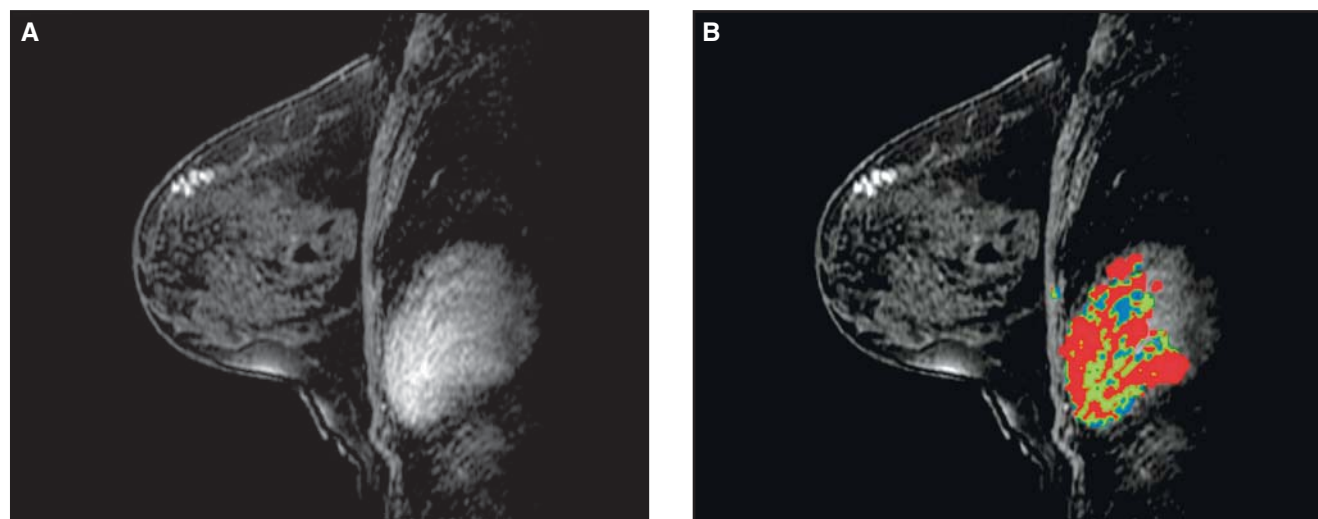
Magnetic resonance (MR) images of a left breast in a 51-year-old asymptomatic woman with a history of prior right breast carcinoma. A. Sagittal, fat-suppressed, T1-weighted, 3-D spoiled gradient recalled immediate postgadolinium image demonstrates nonmass-like segmental enhancement in the upper inner quadrant. B. Same image with computer-aided evaluation applied demonstrates the lesion does not meet the minimum enhancement threshold of 100%, indicated by lack of color overlay at the site. The lesion also did meet the enhancement threshold of 50% (not shown). MR biopsy demonstrated benign fibrosis and ductal hyperplasia. (Image courtesy of Wendy DeMartini, M.D., University of Washington Medical Center, Seattle, Wash. From: DeMartini W, Williams T, Lehman C, Peacock S, Partridge S. Analysis of a computer-aided evaluation program for breast MRI in discriminating benign from malignant lesions [abstract]. RSNA. 2005; SSM01-03.)
